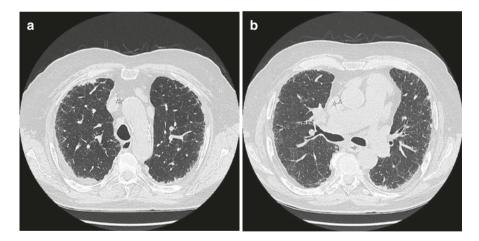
(a) HRCT of the lung: irregular reticulations. (b) HRCT of the lung: symmetric subpleural reticulations. (c) HRCT of the lung: reticulation and patchy areas of GGO. (d) HRCT of the lung: reticulation, and also traction bronchiolectasis apparent in the periphery. Quite insignificant GGO is present. (e) HRCT of the lung (coronal reconstruction): reticulations, predominance of the changes peripherally and basally. (f) HRCT of the lung (mediastinal window): thickening of the parietal pleura (pleural plaques) with calcifications. On the right, a dorsobasal concurrent inconspicuous fluidothorax is noted
